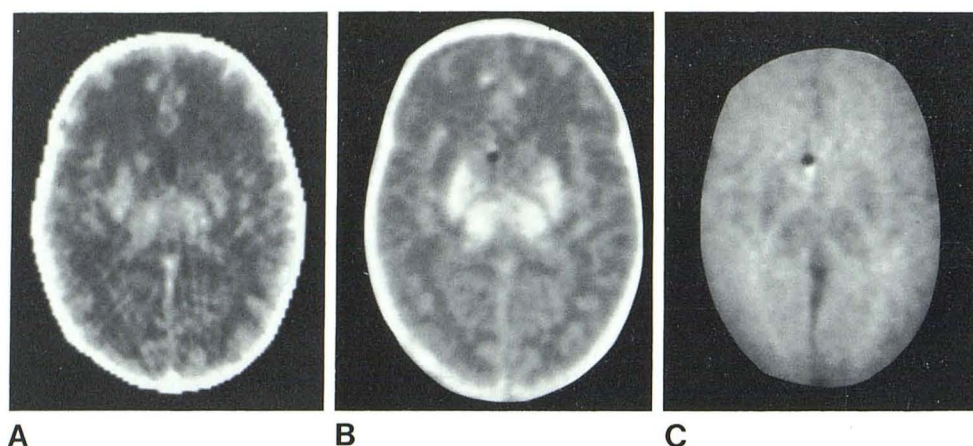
Abnormal NMR scans in infant born at 35 weeks gestation and examined at 2 weeks postnatal age (37 weeks PMA). A, CT scan. Extensive low attenuation throughout cerebral hemispheres with increased attenuation in basal ganglia. Long  $T_1$  throughout cerebral hemispheres with short  $T_1$  (B,  $IR_{1800/600}$ ) and short  $T_2$  (C,  $SE_{1160/80}$ ) in basal ganglia.
